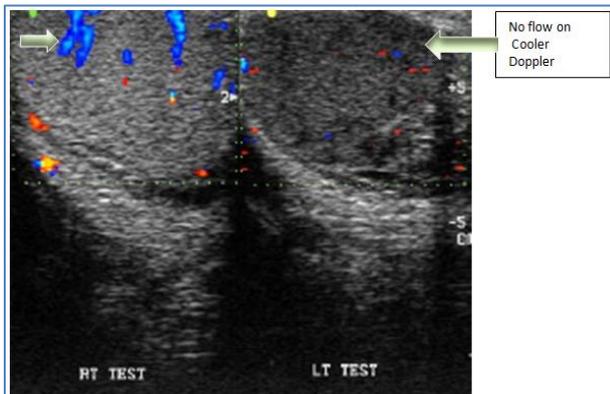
b: Colour Doppler shows absent flow in the left testis (Colour doppler image)
